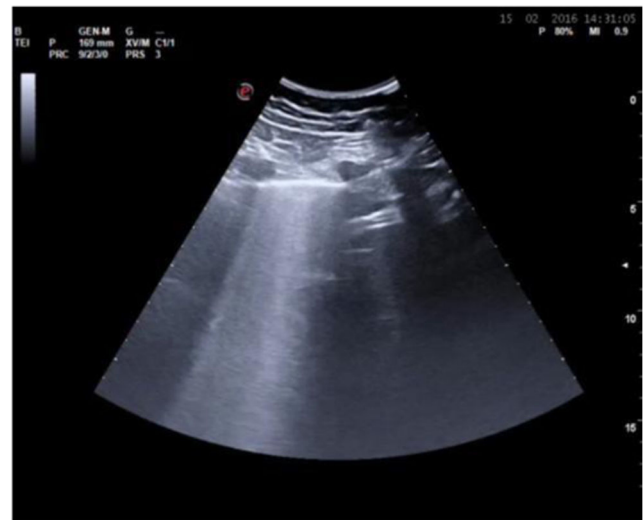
Detection of B lines with lung ultrasound
